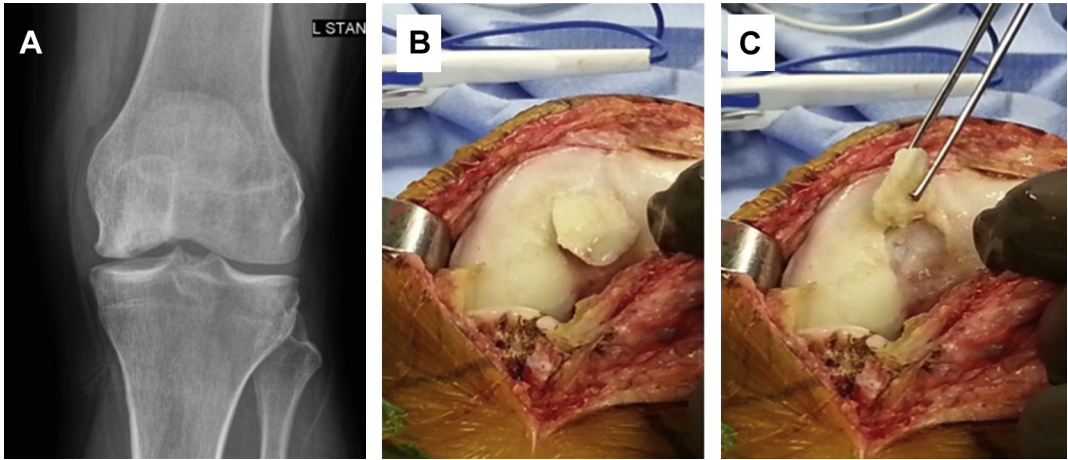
A 39-year-old woman with continued left knee medial compartment pain after undergoing medial femoral condyle osteochondral allograft transplantation. (A) A 45° flexion weight-bearing posteroanterior radiograph demonstrating cystic changes of the left knee medial femoral condyle. (B, C) Osteochondral graft not healed at the time of unicompartmental knee arthroplasty, approximately 1.5 years following transplantation.
